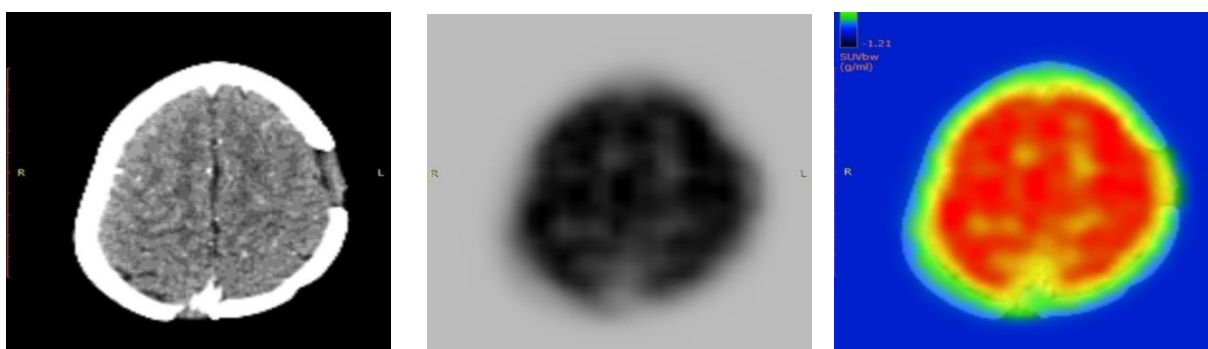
(B): Post therapy Axial CT-FDG PET and fused PET/CT of Skull shows marked metabolic regression with residual lytic bone lesions in CT.
